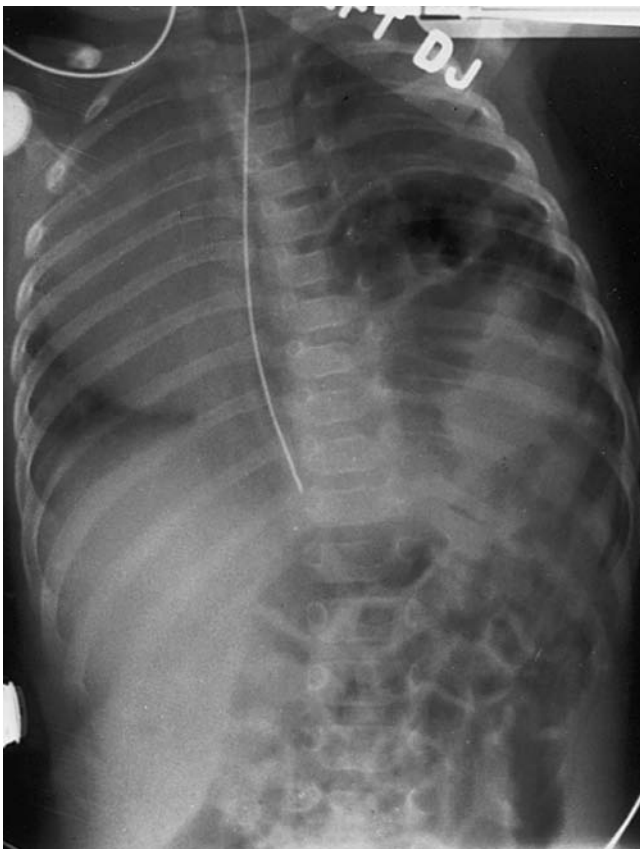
This 2-month-old girl was well until 4 days before admission. She developed congestion and an apparent upper respiratory tract infection. She slowly developed increasing dyspnea and was admitted in acute respiratory distress. A chest radiograph revealed a high left diaphragmatic eventration with a significant mediastinal shift to the right.
